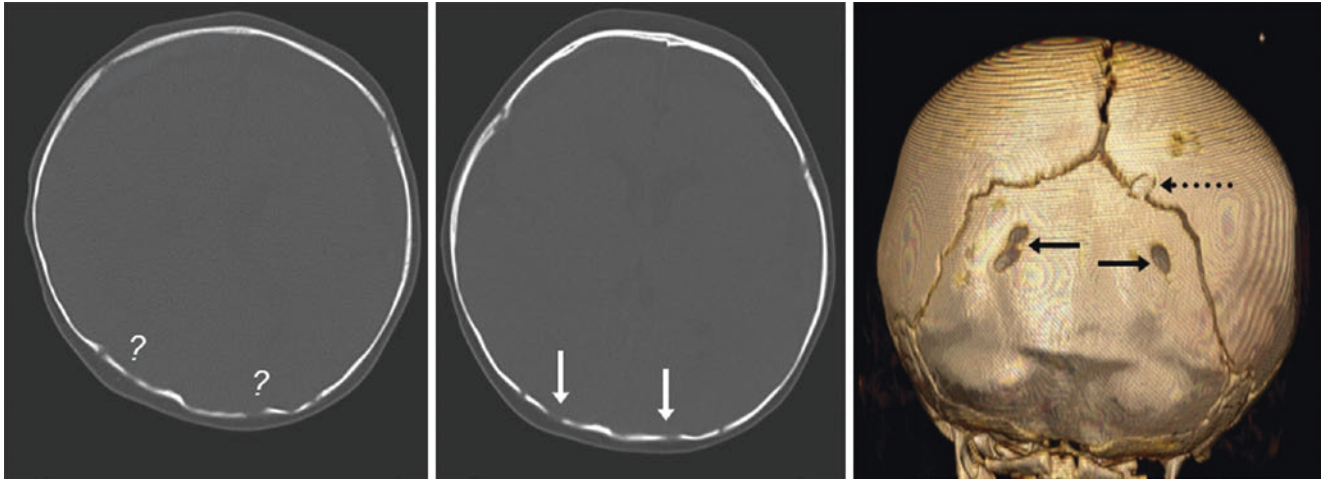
A 6 month old lying obliquely in the CT scanner with curious occipital defects identified after head trauma (?). Axial images (3.5 mm) (*left and middle*) depict the occipital foramina
